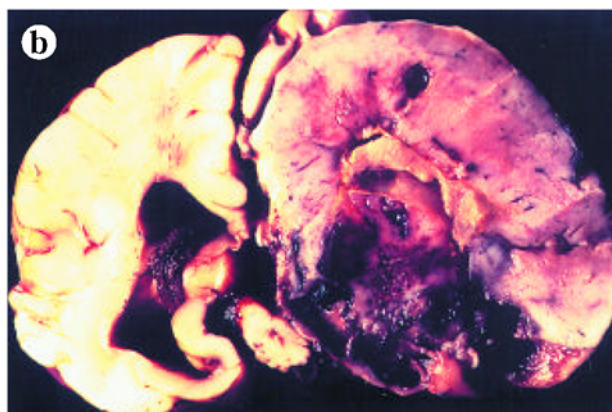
Radiologic and macroscopic appearance of large congenital stPNET a) Contrast-enhanced computed tomography of the skull shows the massive tumor of the right hemisphere with a complex morphology of cystic and solid areas in the tumor with intralesional hemorrhage. The circulation of the cerebrospinal fluid is impaired presenting as hydrocephalus because of compression of the aqueduct. b) The entire right hemisphere consists of a greyish fleshy tissue with a multicoloured appearance with necrotic, hemorrhagic and cystic areas on cut surface.
